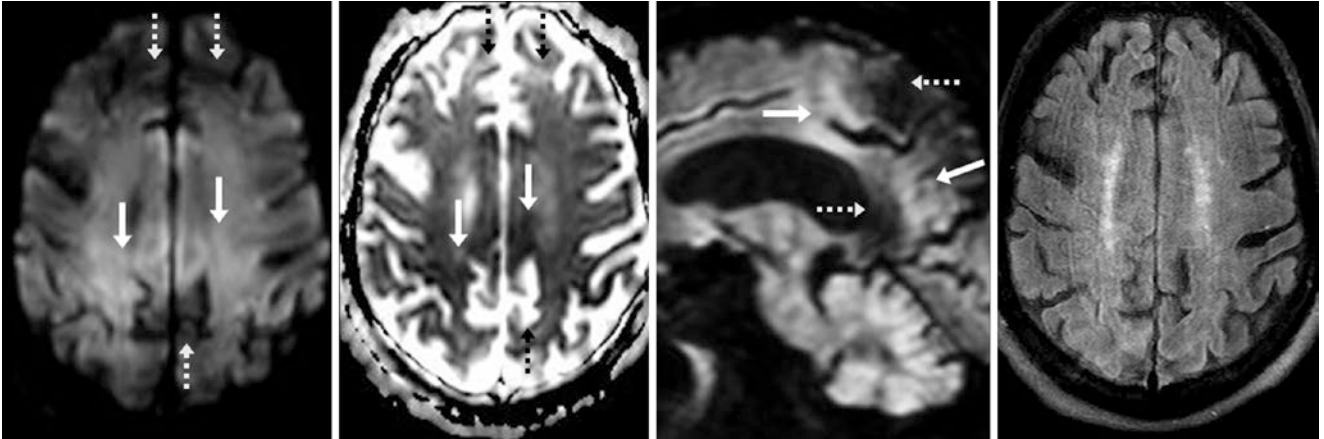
A 3 T MRI from an 80-year-old shows motion artifact causing patchy regions of both bright signal (*arrows*) and dark signal (*dashed arrows*) on DWI (*left*), with the reverse appearance on an ADC map (*left middle*). A sagittal DWI (*right middle*) was obtained, which
